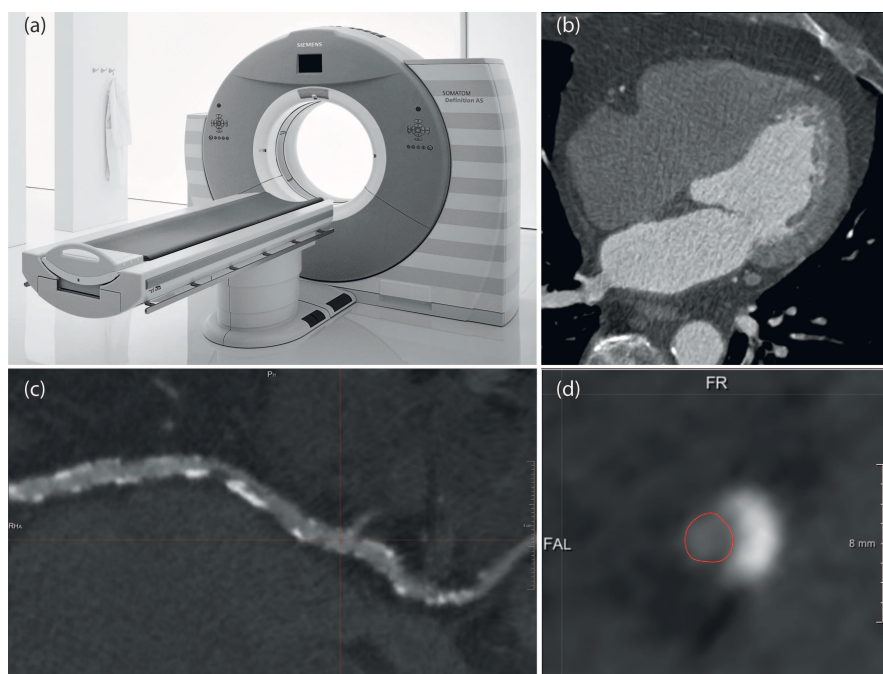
Computed Tomography Coronary Angiography. (a) CT scanner (Somatom Definition, Siemens, Forchheim, Germany). (b) Example of axial image. (c) Longitudinal view of a curved planar reformatted image of a left circumflex coronary artery. (d) Cross-sectional view of a curved planar reformatted image of a left circumflex coronary artery, presenting a calcified plaque.
